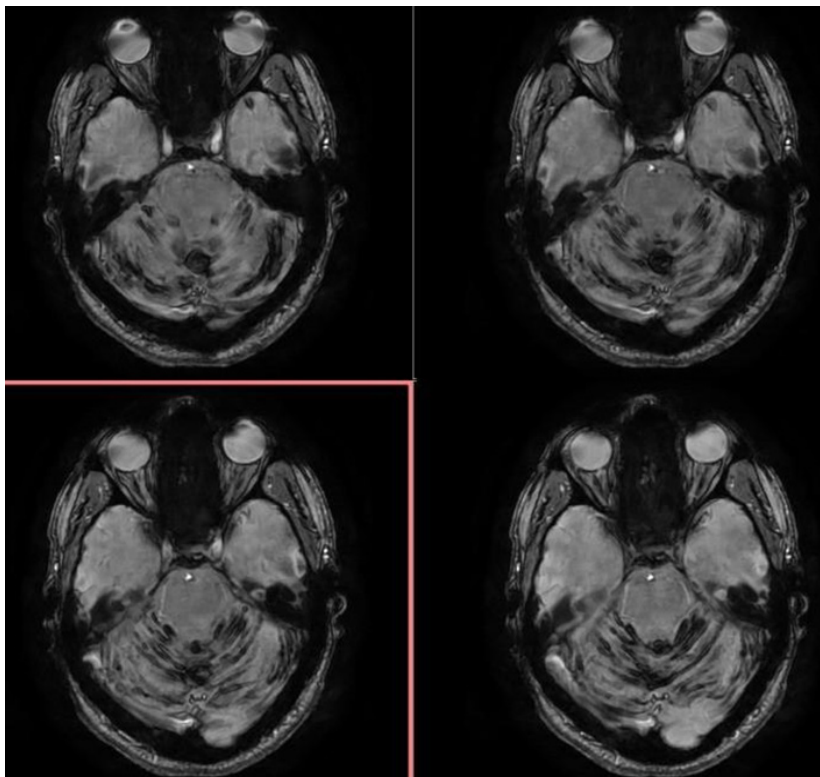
Brain MRI with CSF flow study showing hyposignal compatible with SSI in the cerebellum, left anterior transverse temporal gyrus, bilateral parietotemporal transitions and bilateral frontobasal convexity. 2024. Available at: personal archive author MKFP.
